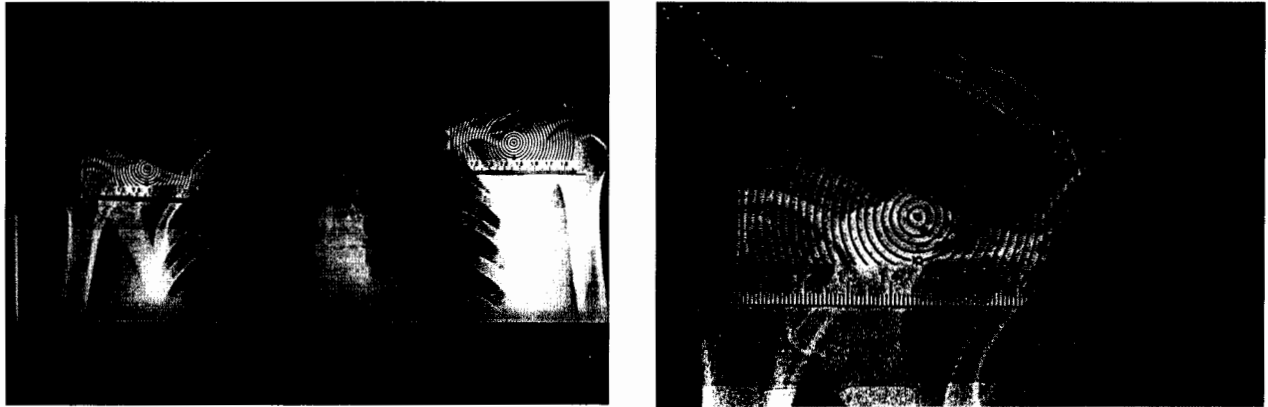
The radiograph of both AC joints and technique using Mose's template to measure the CC distances.
